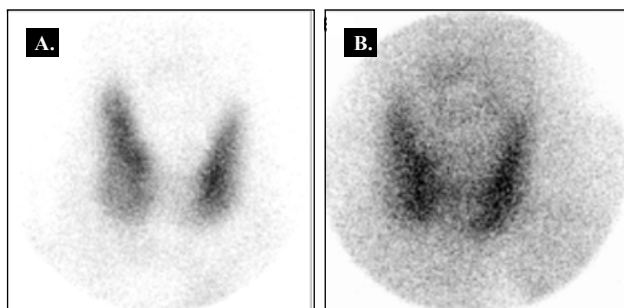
Thyroid scintigraphy showed a "cold" thyroid nodule at 30min post injection of 370MBq ^{99m}Tc -pertechnetate in the lower part of right lobe of the thyroid gland (A). This nodule showed a "positive result" at 30min after injection of 740MBq ^{99m}Tc -methoxy-isobutyl-isonitrile (B).
